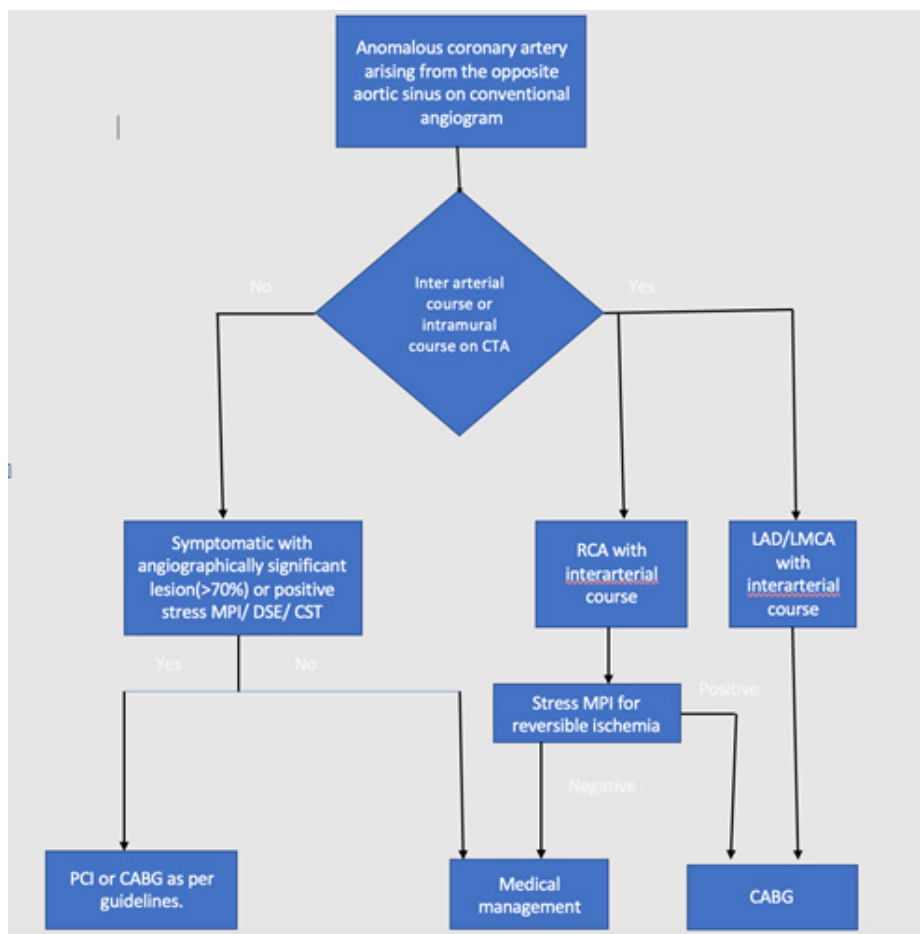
Proposed management algorithm of anomalous coronary arteries and their management. (Abbreviations: CTA: CT Angiography; MPI: Myocardial Perfusion Imaging; DST: Dobutamine Stress Test; CST: Cardiac Stress Test; PCI: Percutaneous Coronary Interventions; CABG: Coronary Artery Bypass Grafting; RCA: Right Coronary Artery; LAD: Left Anterior Descending; LMCA: Left Main Coronary Artery).
